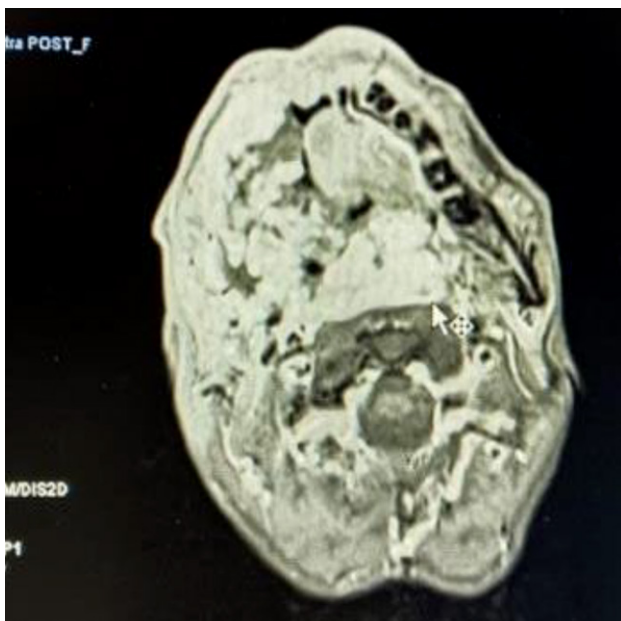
T1weighted MRI neck (axial) with contrast showing heterogeneously enhancing mass lesion in the area of hard palate and soft palate with extension
